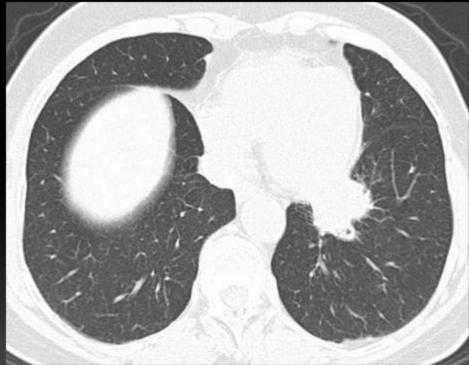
Man, 68 years old, ex-smoker and with hemoptysis. Thoracic CT shows a left justamediastinal mass with heterogeneous enhancing and spiculated contours (corona radiata). Biopsy confirms the diagnosis of lung cancer.
